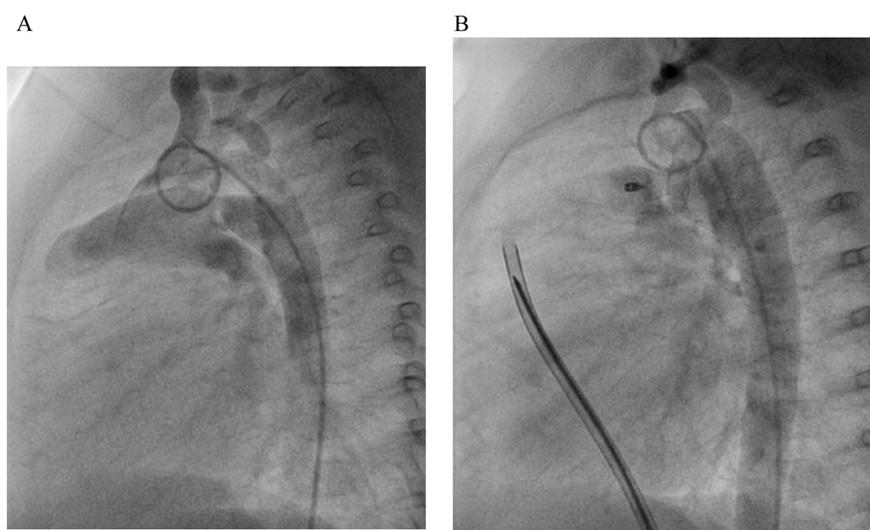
(A) Aortography in lateral projection. Large type A PDA measuring 2.81 mm at its narrowest diameter. (B) Control angiography after implantation of a 5/7 short shank device showing a small residual shunt. This shunt was fully closed on control echocardiography at day one.
